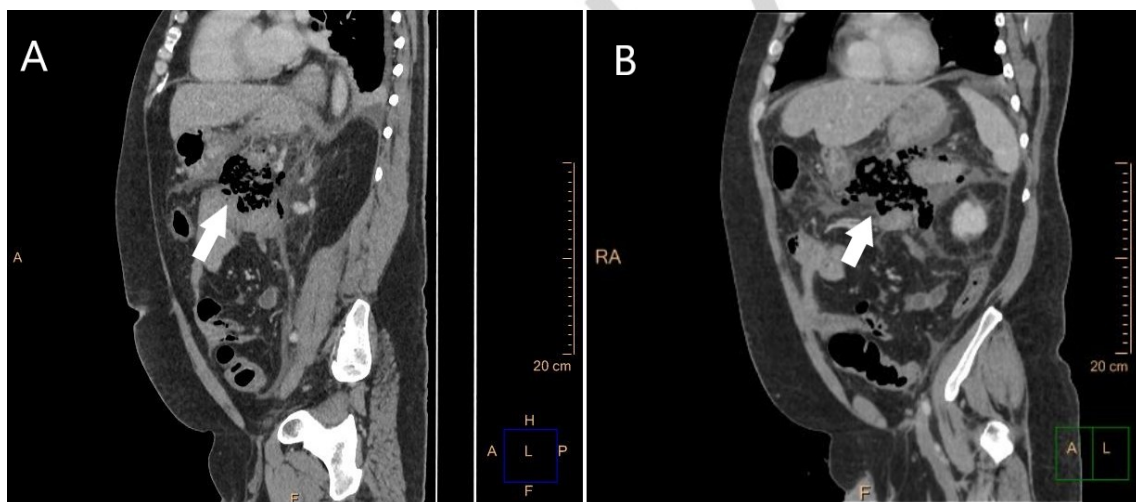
Abdominal CT with intravenous contrast in portal phase shown in sagittal (A) and oblique (B) views, focused in the pancreas, parcial replacement of the distal body and the tail of the pancreas by an aerial collection (white arrow) that extends adjacent to the first jejunal loop, which appeared thickened and with signs of inflammation, but without discontinuity in its wall.
